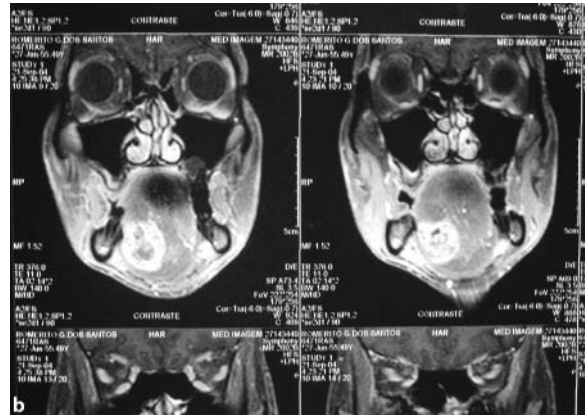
a Clinical picture of adenoid cystic carcinoma of the right sublingual gland. b A coronal view (T1-weighted) of the same tumor on MRI revealing its relationship with the lingual aspect of the mandible and muscles of the oral tongue and floor of the mouth
